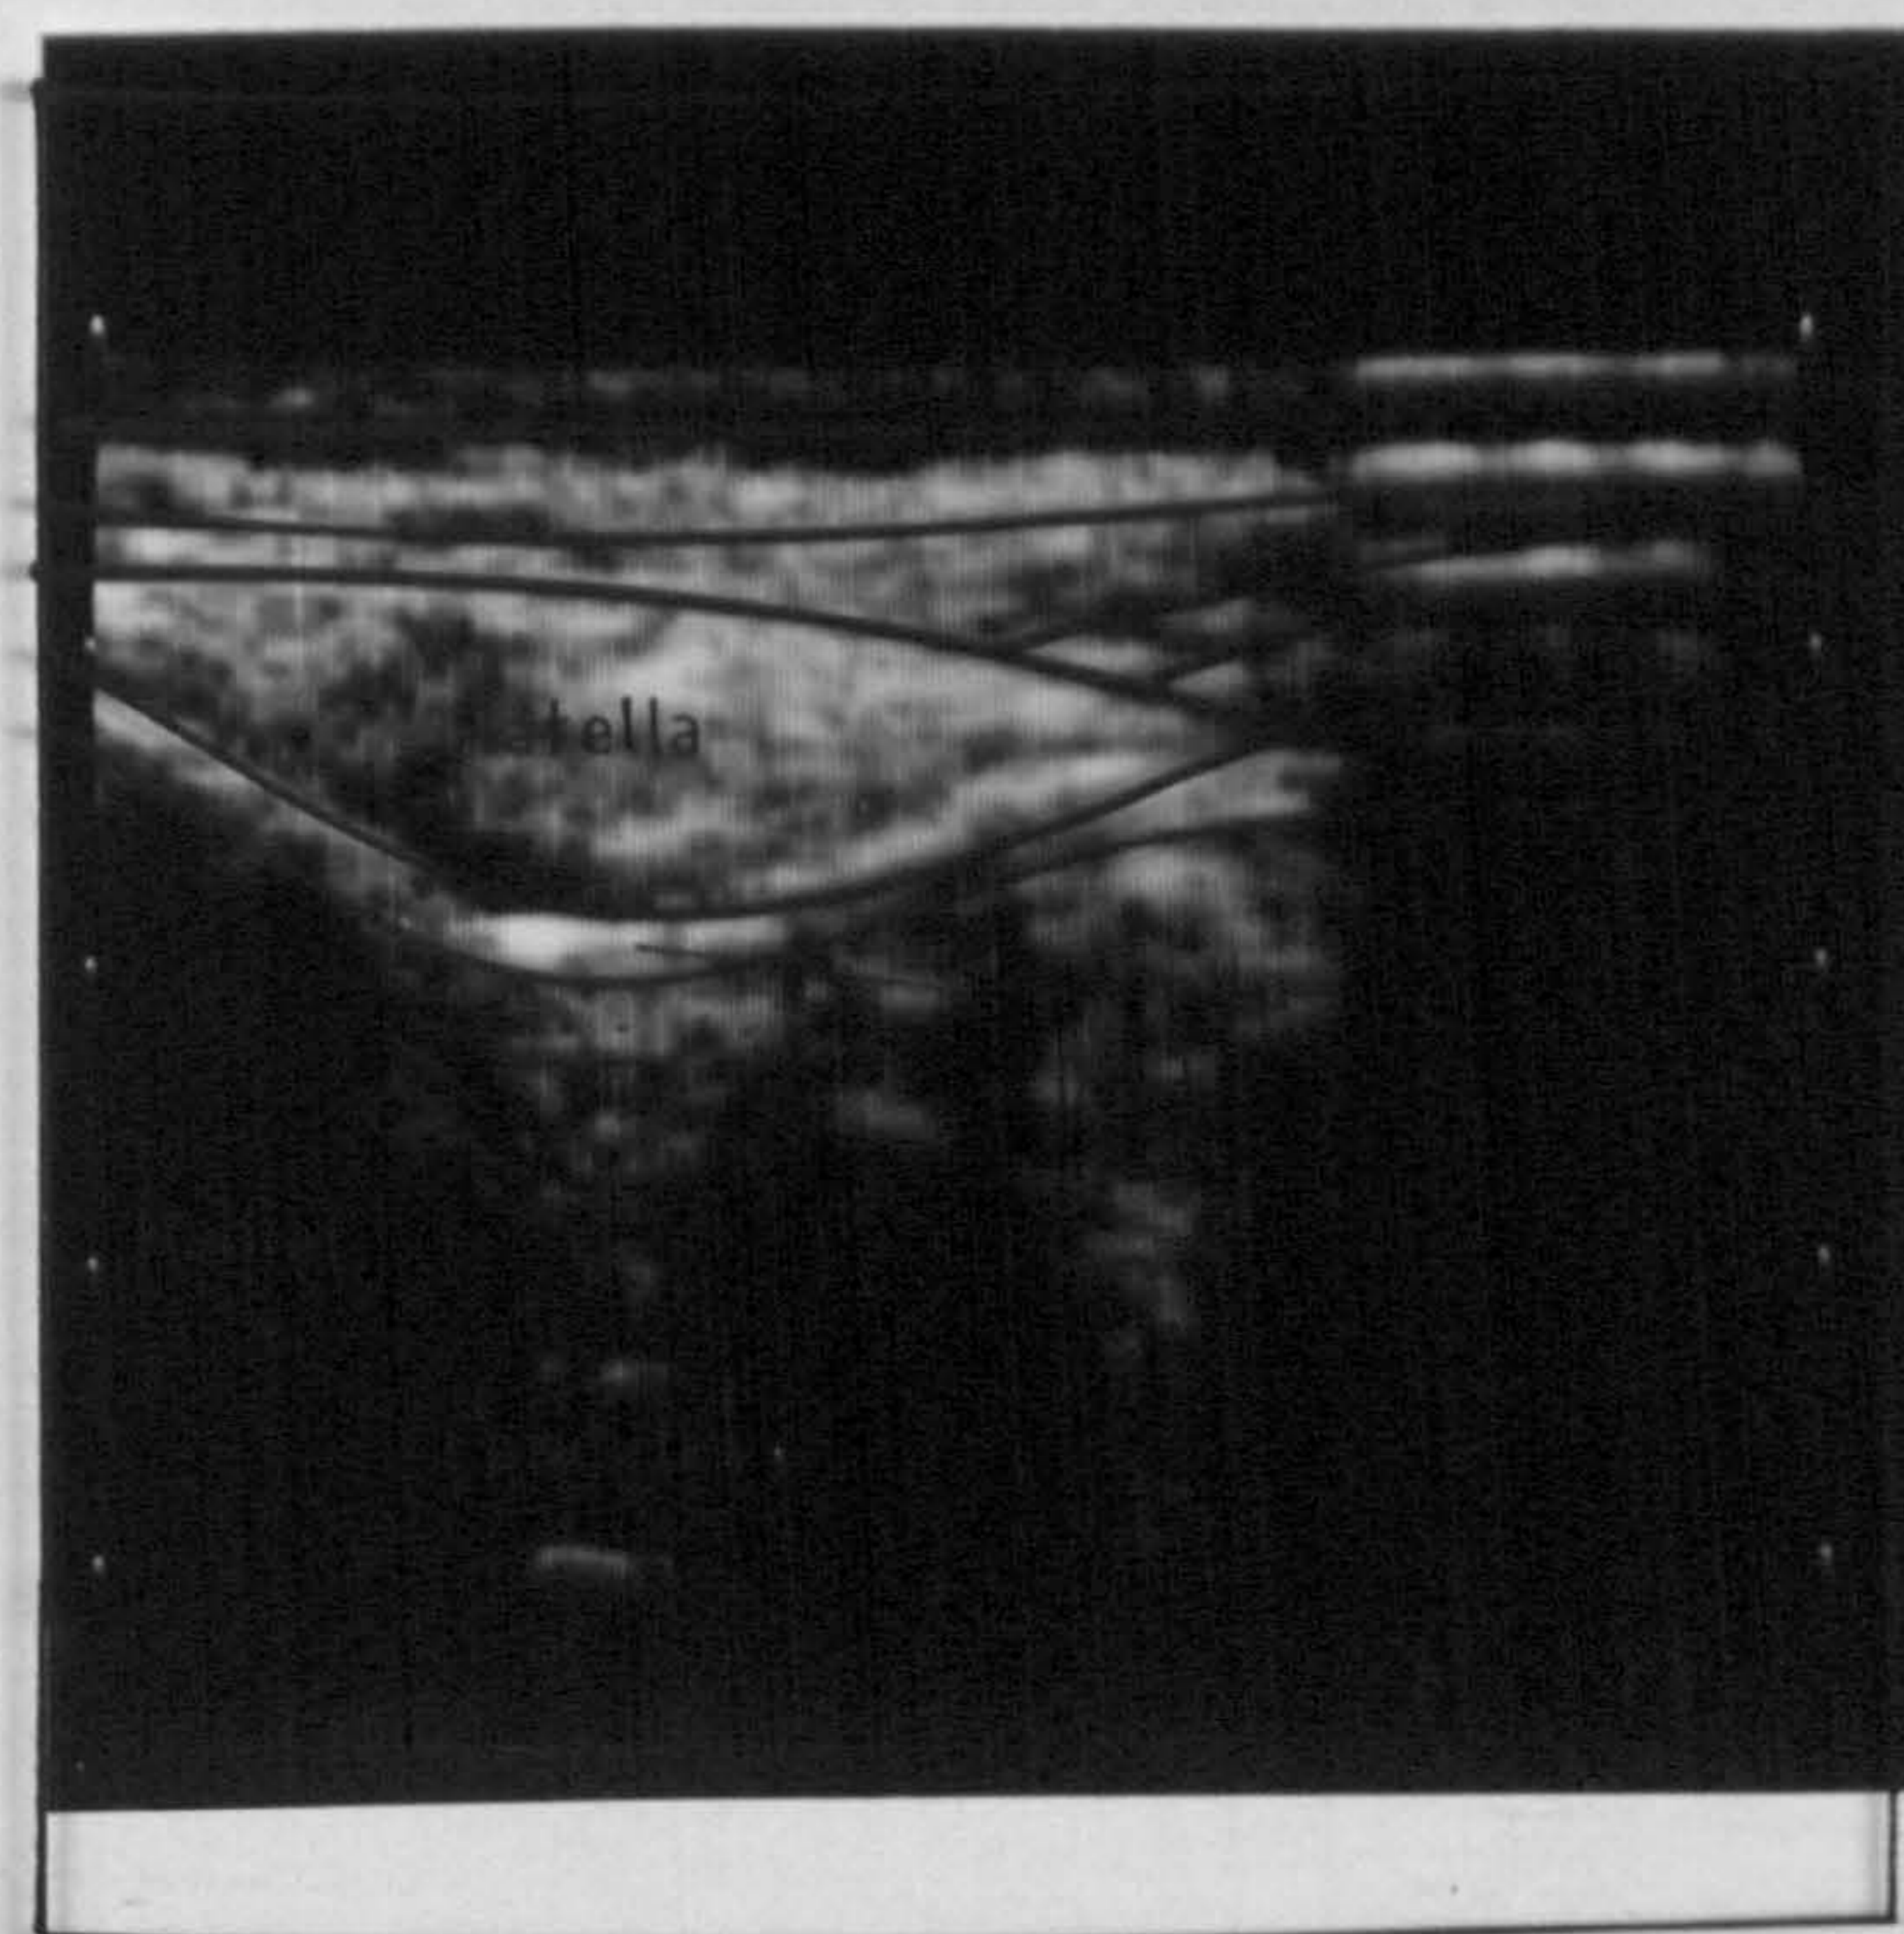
b Ultrasound scan right knee : skyline view
